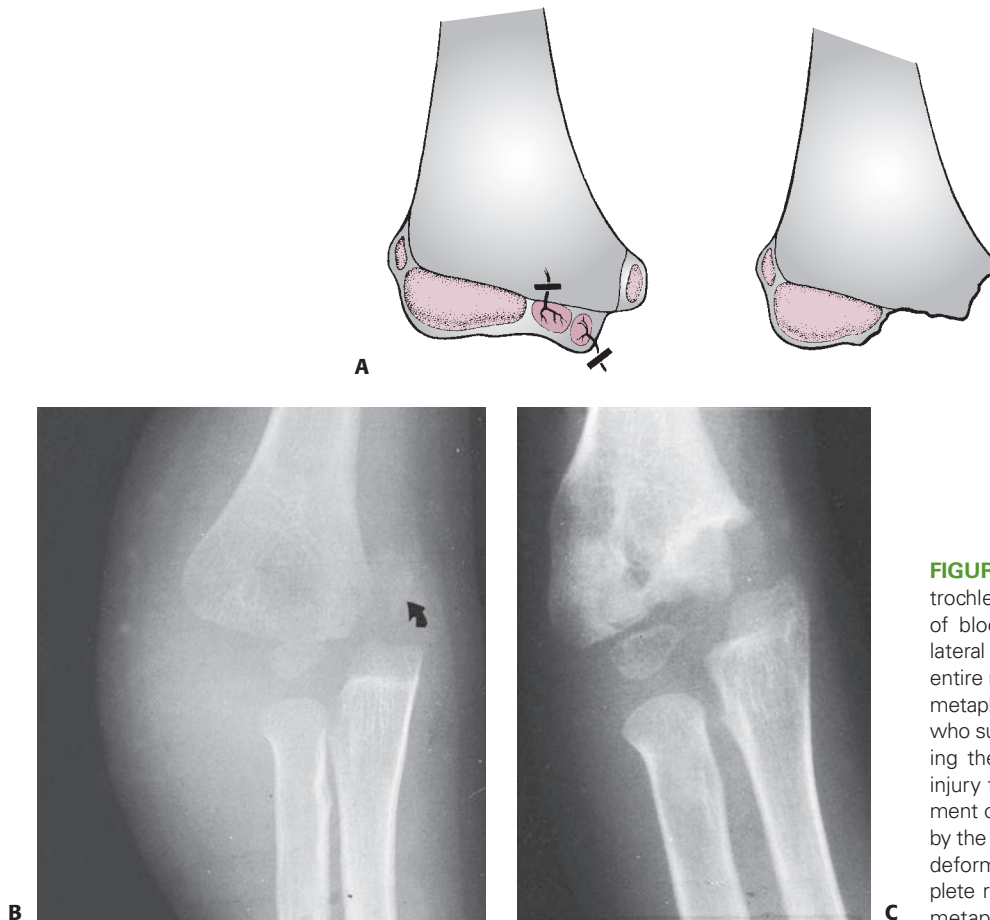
Osteonecrosis of the entire trochlea. A: In this type B deformity, loss of blood supply from both the medial and lateral vessels results in osteonecrosis of the entire medial crista along with a portion of the metaphysis. B: Radiograph of a 4-year-old boy who sustained a type II physeal fracture involving the entire distal humeral physis. In this injury film, there is a large metaphyseal fragment on the medial side (*arrow*). C: As shown by the appearance 5 months later, a mild varus deformity is present because of an incomplete reduction. The ossification in the medial metaphyseal fragment has disappeared.
